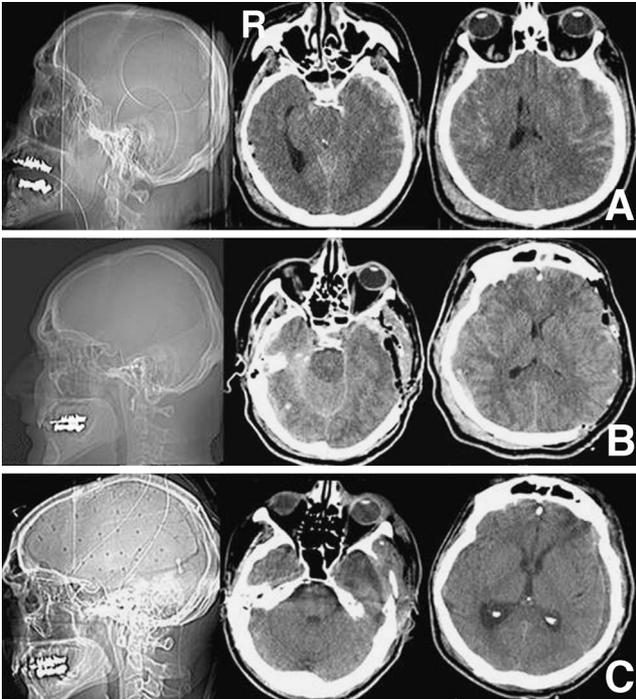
Case 1. A: Computed tomography (CT) scout view and axial CT scans on admission showing a left acute subdural hematoma with multiple internal herniations. B: Postoperative CT scout view and axial CT scans demonstrating a large fronto-temporo-parietal decompressive craniectomy, subdural hematoma evacuation, and complete midline realignment with resolution of the intracerebral herniations. C: CT scout view and axial CT scans after cranioplasty showing the full coverage of the bone defect.
